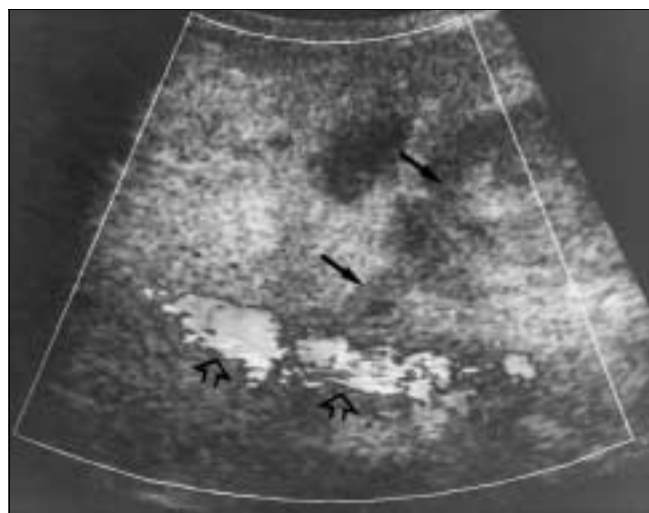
Doppler ultrasound performed immediately after thrombin injection in the same patient. There is no flow within the pseudoaneurysm. Echogenic fresh thrombus is seen within the neck and cavity of the pseudoaneurysm (arrows). Flow remains unchanged in the native artery (open arrows).
